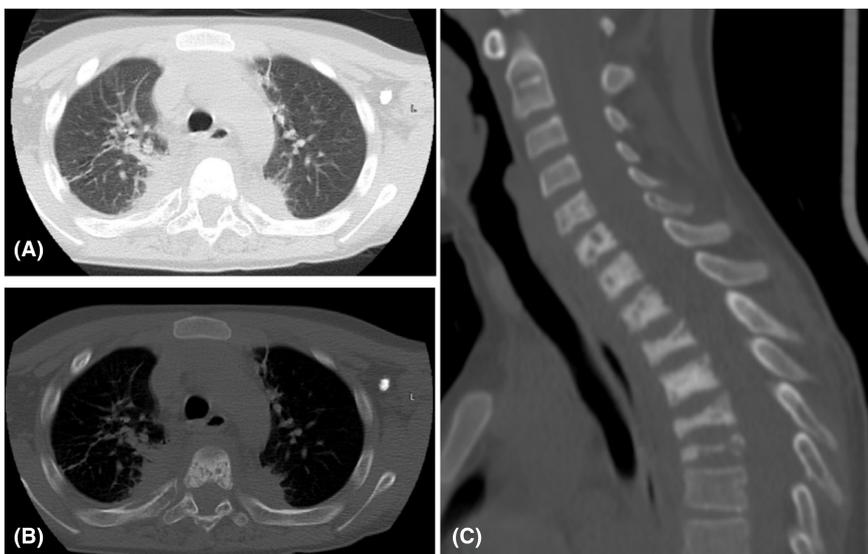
(A) Axial CT scan in pulmonary window shows bilateral peripheral consolidation in superior segments of both lower lobes. (B) Axial CT scan image in bone window shows right-sided adjacent rib involvement. (C) Reconstructed sagittal CT scan image shows lytic-sclerotic lesions on multiple vertebral bodies and vertebra plana at T2, T4, and T5 vertebrae. These findings are consistent with pneumonia with rib osteomyelitis and multi-level vertebral body spondylitis.
